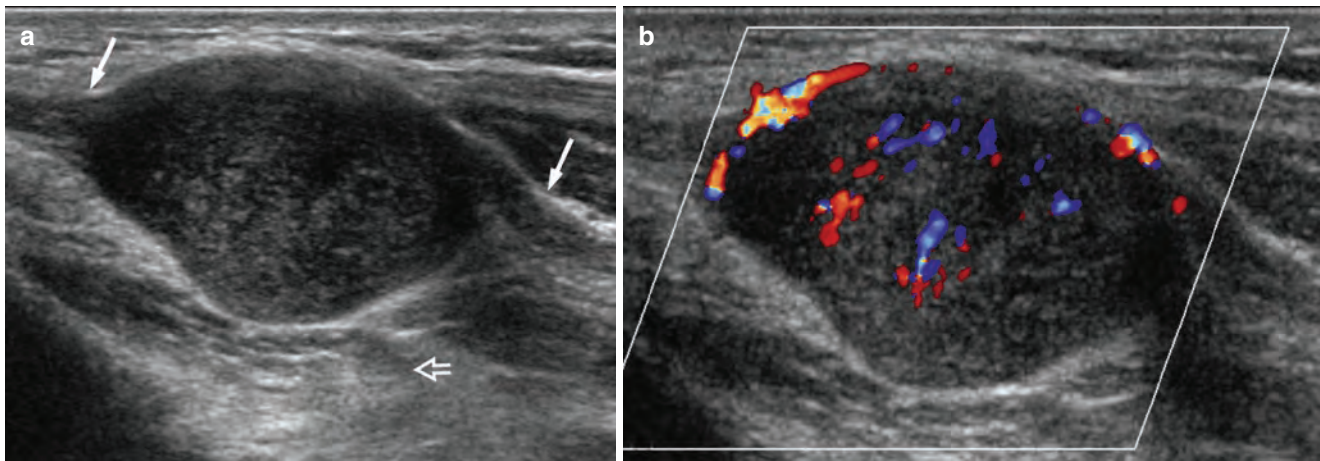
Longitudinal ultrasound of distal forearm showing (a) medium-sized nerve sheath tumour arising eccentrically from the median nerve (arrows) with neural continuity and acoustic enhancement (open arrow). (b) The tumour shows moderate tumoural hyperaemia. These are diagnostic ultrasound appearances of a nerve sheath tumour
